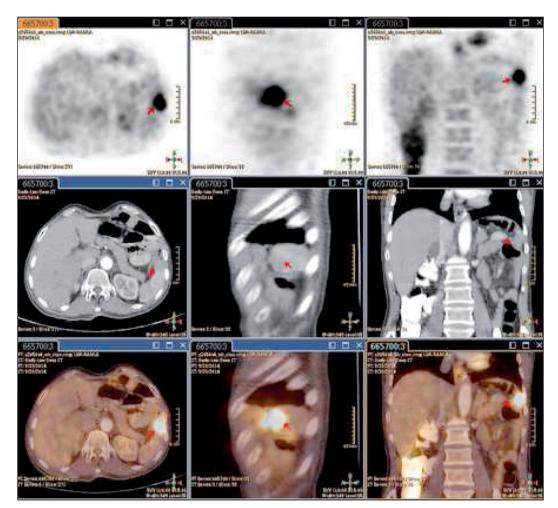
In gastric cancer case, isolated solitary splenic metastasis is seen in image of PET (1st row), CT (2nd row) and PET/CT fusion (3th row) with red arrow.
